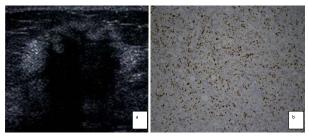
A) Ultrasound Imaging of ER/PR (+): Spiculated Margin Contour, Absence of Calcification, Posterior Tumor Shadowing; Presence of Echogenic Halo. B) Result of IHC: ER-Positive
